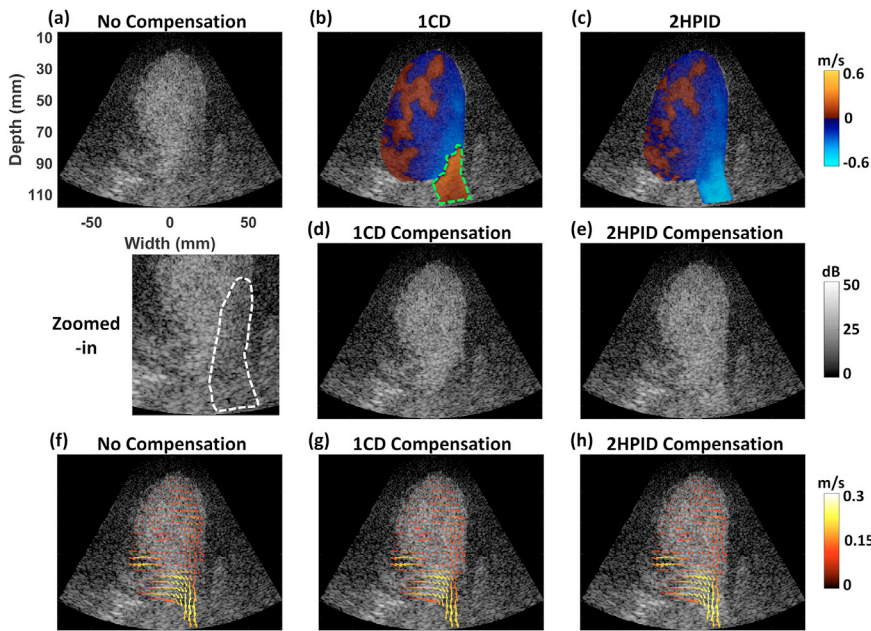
Example apical three-chamber left-ventricular images in patient 1 during ventricular ejection ($t = 0.71$ s). (a) HFR CEUS B-mode image with no compensation and its zoomed-in image. (b) Axial velocity images from 1CD and (c) 2HPID; B-mode images after (d) 1CD- and (e) 2HPID-based phase compensation. EchoPIV images before (f) and after (g) 1CD- and (h) 2HPID-based compensation. White and green dashed windows indicate the original decorrelation region and aliasing region, respectively. 1CD, fundamental-mode color Doppler, and 2HPID, second-harmonic pulse inversion Doppler; CEUS, contrast-enhanced ultrasound; HFR, high-frame-rate.
